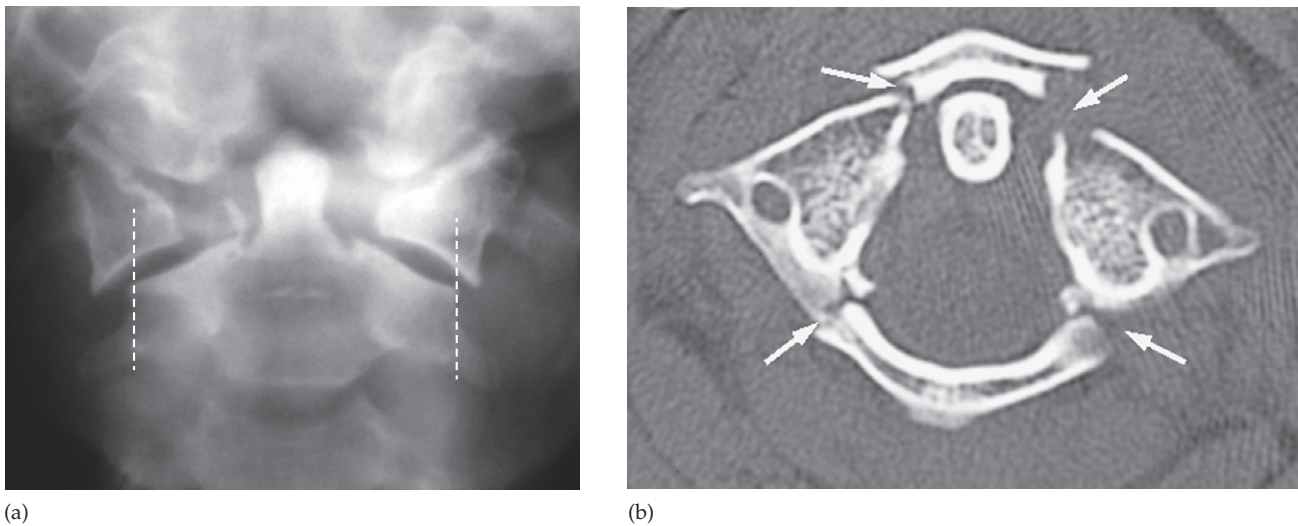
Jefferson's fracture. (a) Plain film showing overlap of the articular pillars of C1 beyond the margins of the C2 vertebral body (dashed lines) due to a burst fracture of C1 (compare with the normal radiograph in Fig. 13.10). (b) Axial CT showing the fractures of the posterior arch more clearly together with fractures of the anterior arch (arrows).
